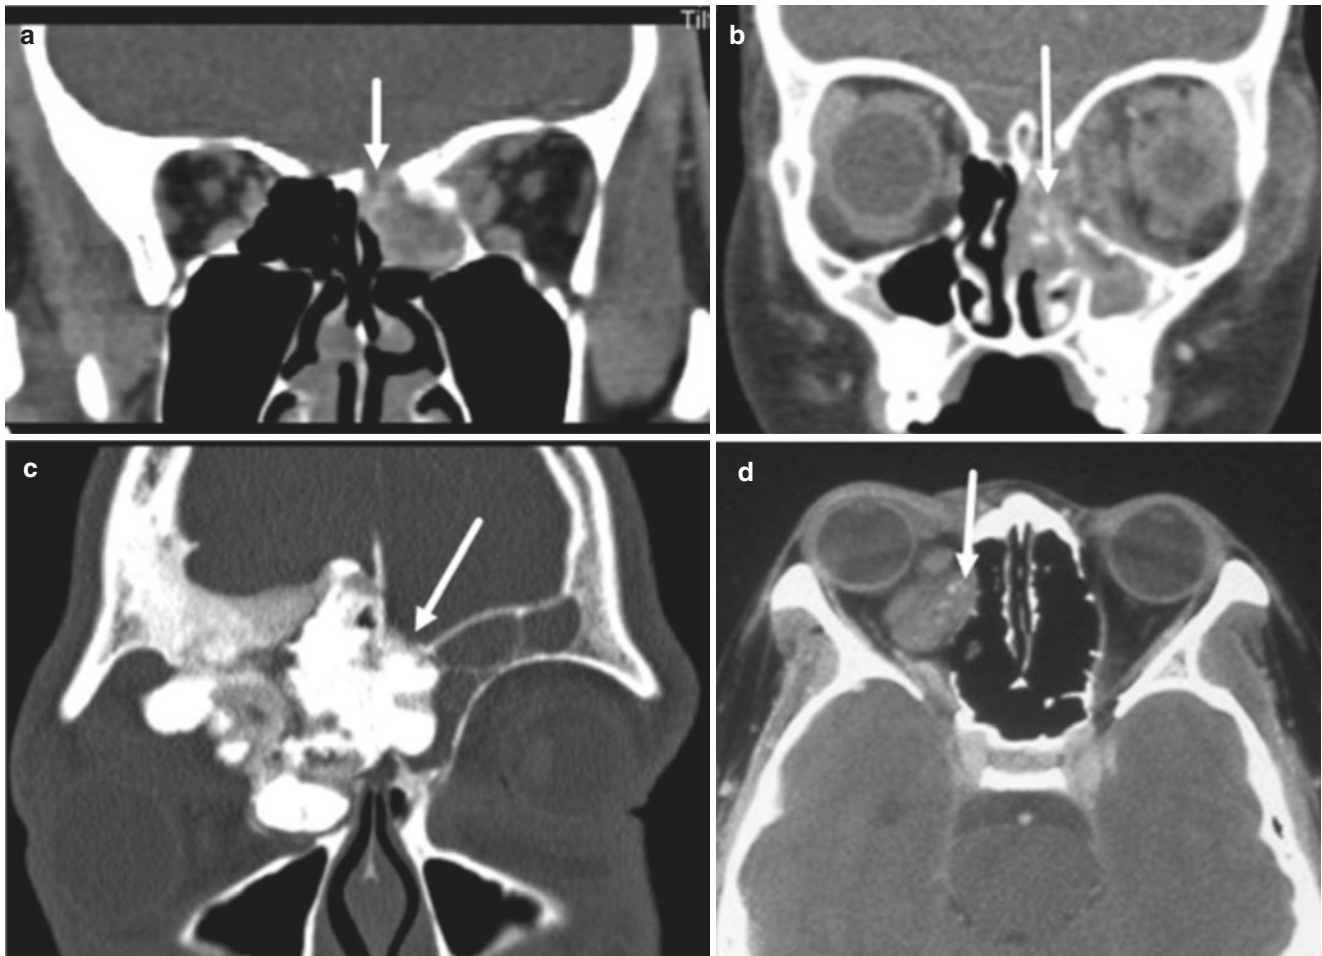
(a) Coronal CT scan showing sinus tumour eroding the base of the skull (arrow). (b) Note the bony erosion of the medial orbital wall in a sinus tumour (arrow). (c) Bony lesion of the orbit. (d) Calcification in a vascular malformation
